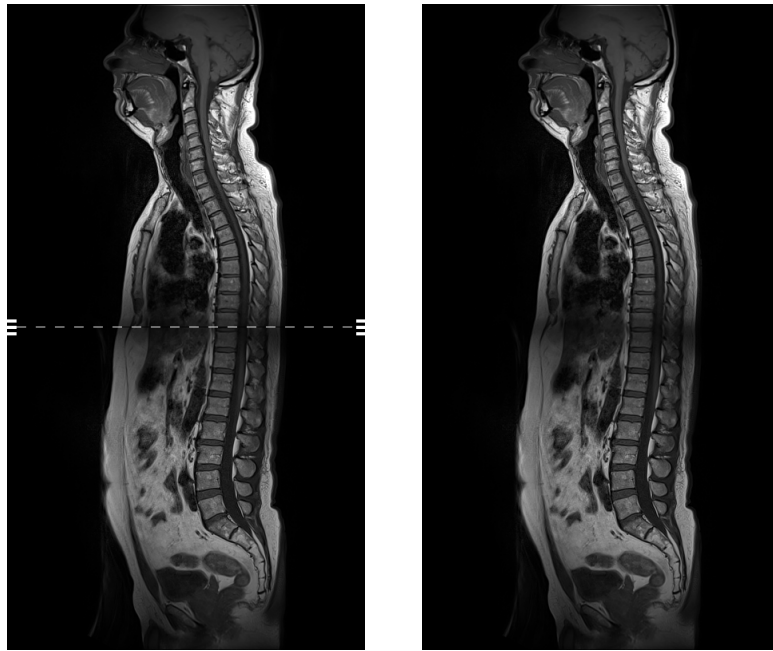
Midsagittal T1-weighted MR slice unprocessed (left) and processed (right)
